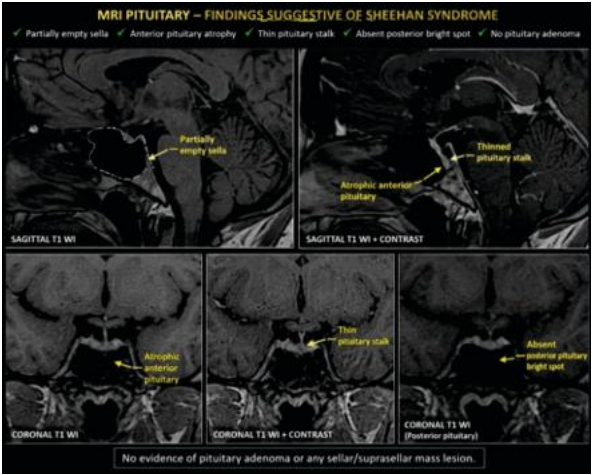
Magnetic Resonance Imaging of the Sellar Region Demonstrating a Partially Empty Sella with Marked Anterior Pituitary Atrophy, Thinning of The Pituitary Stalk, And Absence of the Normal Posterior Pituitary Bright Spot, Consistent with Sheehan Syndrome Involving Both the Anterior and Posterior Pituitary.
